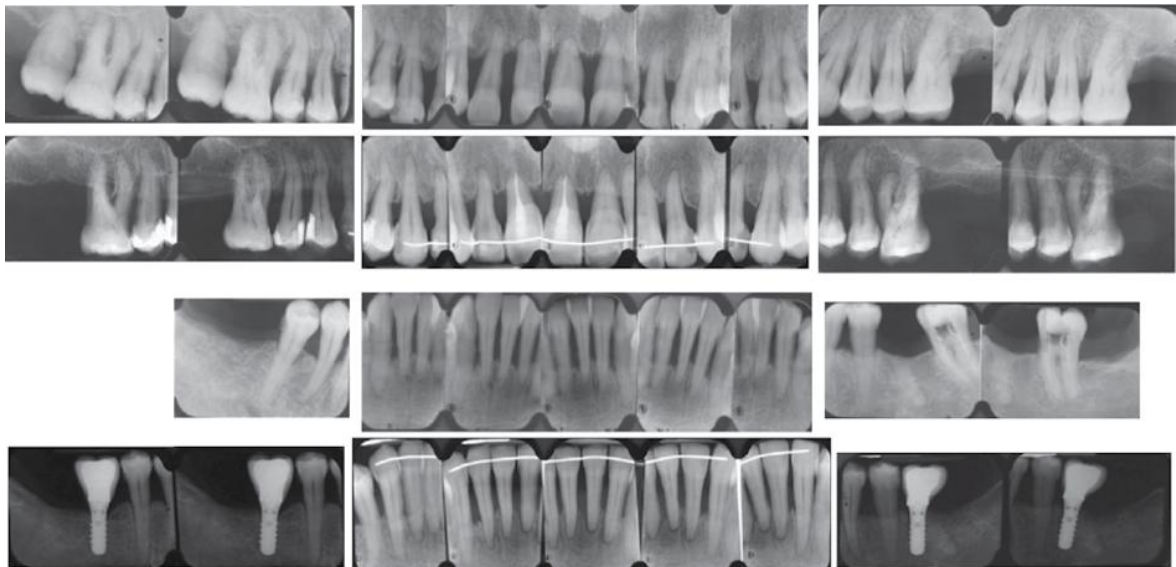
(Continued) (c) Orthodontic treatment progress, lower arch appliances first and preventive root canal treatment prior to upper arch appliances. (d) Orthodontic treatment progress. (e) Follow-up periapical series and OPG.
